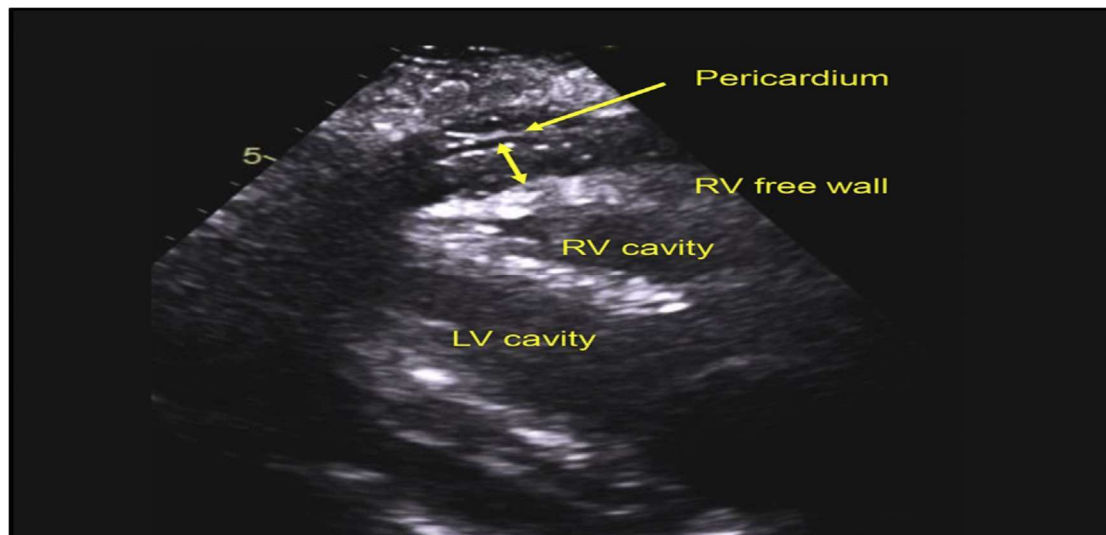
In obese HFpEF, there is noticeable epicardial fat. End-systole parasternal long-axis image of a patient with HFpEF who is obese (BMI: 38 kg/m²). Take note of the 14 mm increase in epicardial fat thickness between the pericardium and the RV free wall.
